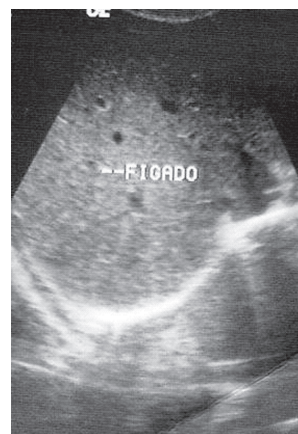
Ultrasonography - thickness of the gallbladder wall (7.0mm).Figure 2. Ultrasonography – hepatomegaly.
